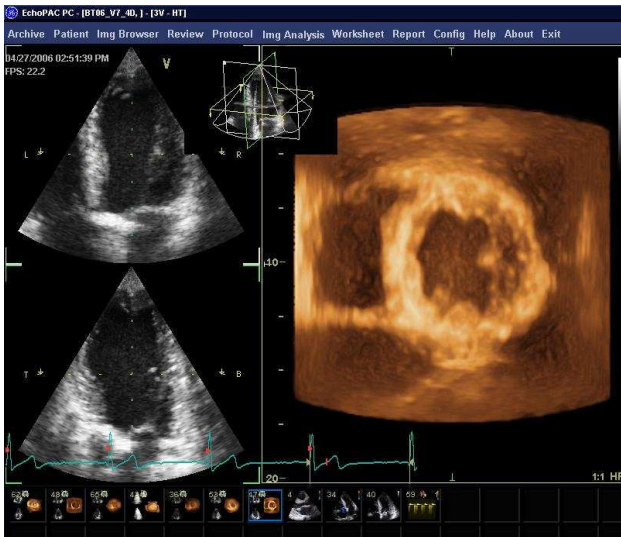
EchoPac display of 3D echocardiographic data. A volume rendered representation is shown on the right while cut-planes of 4 and 2-chamber views are displayed to the left.
